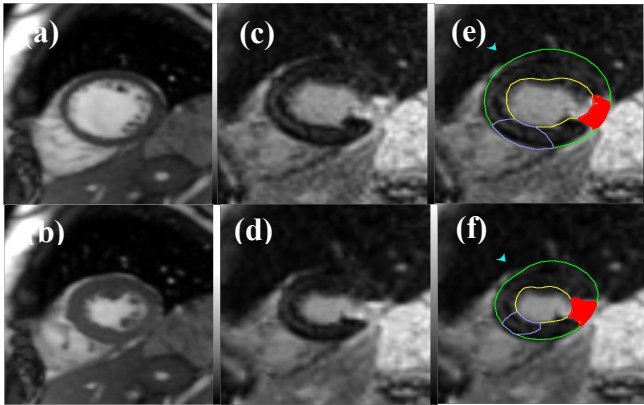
MRI Cine images at (a) end diastole and (b) end systole, as well as the corresponding synthetic DE images (c,d). Palettes (e) and (f) show the DE regions (red) and wall thickening for the two synthetic DE images.
